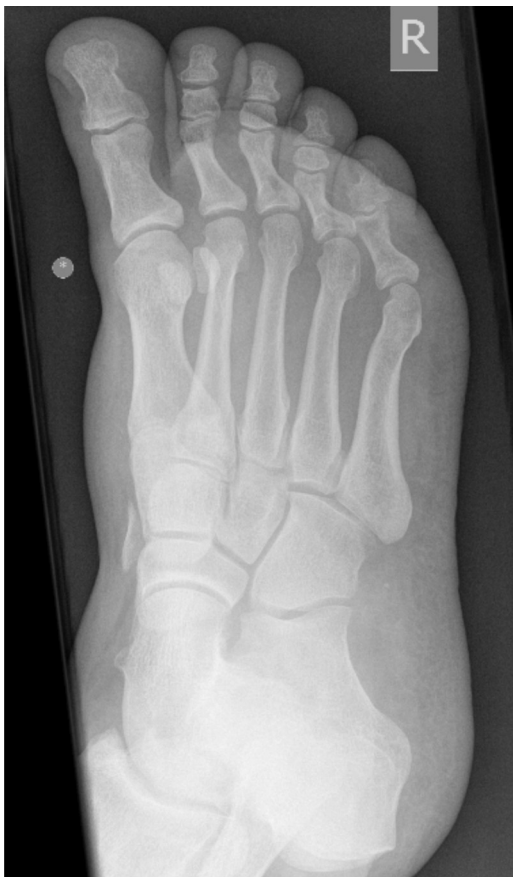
Radiograph showing avulsion fracture from the medial cuneiform and base of first metatarsal.
